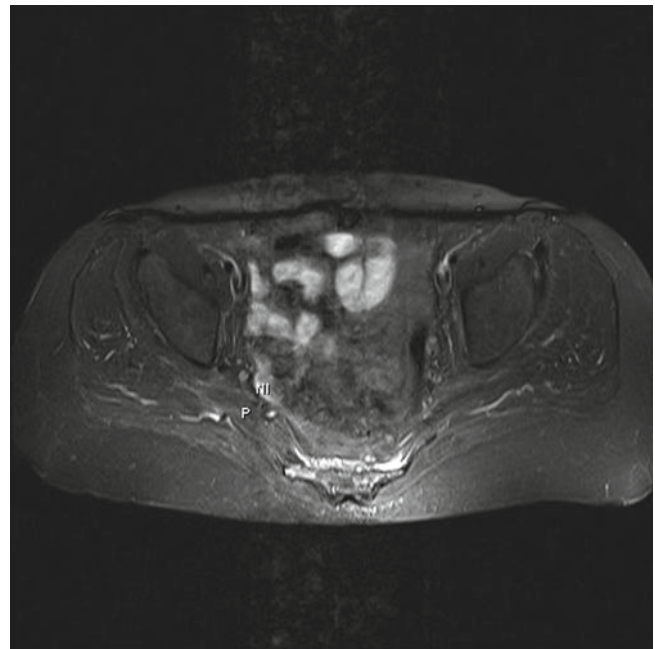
A normal magnetic resonance image of the piriformis muscle (*P*) and sciatic nerve (*NI*) (Reproduced with permission from Danilo Jankovic)
